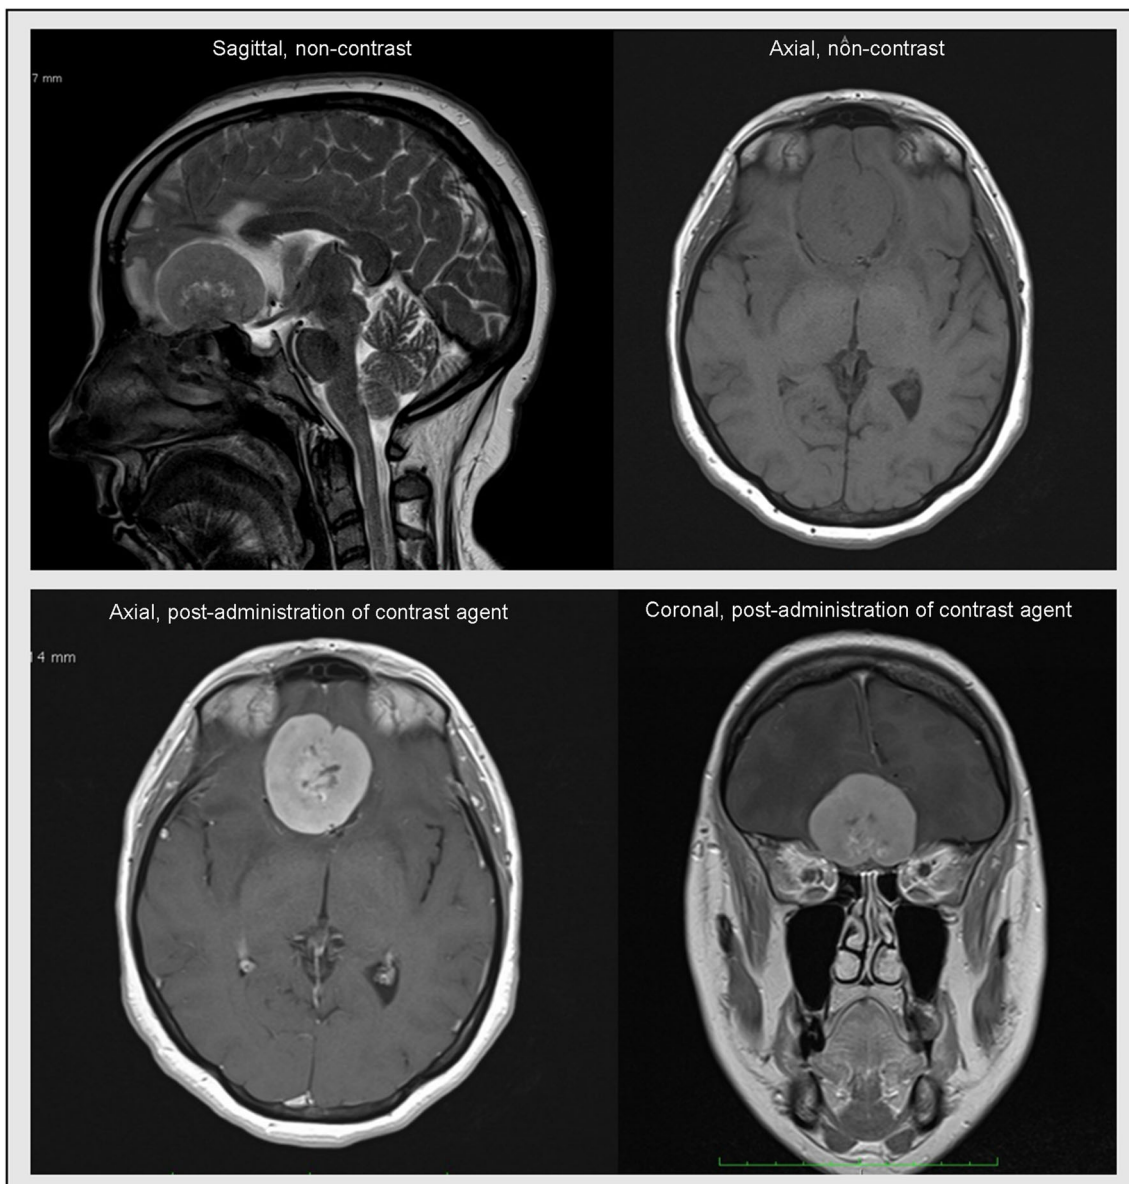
T1- and T2-weighted MRI scans acquired in sagittal, axial, and coronal planes with 1.5 T show a large extra-axial, contrast-enhancing mass located in anterior cranial fossa (olfactory groove), which is compatible with meningioma
